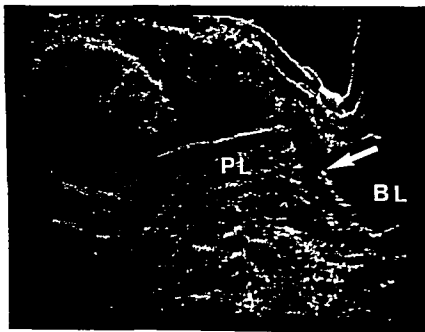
Ultrasonic B-scan at the 37th week from the same patient as in Fig 5. Placenta is still in the same previous location on the posterior wall of the uterus
